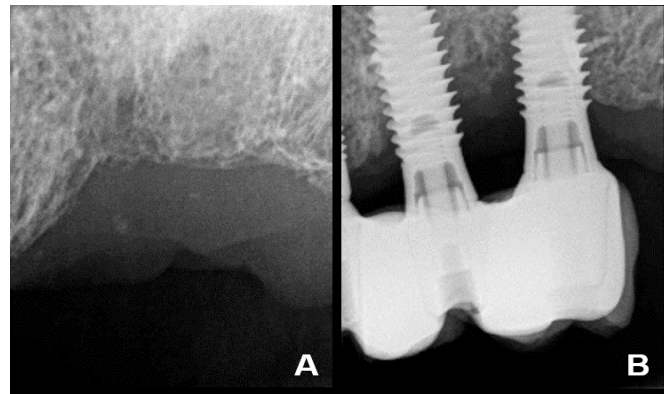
(A) Intraoral periapical radiograph showing an irregular radiolucency following tooth-extraction of 2.5 (2010). (B) Intraoral periapical radiograph revealing the marginal bone loss around implants 2.5 and 2.6 (2021).
